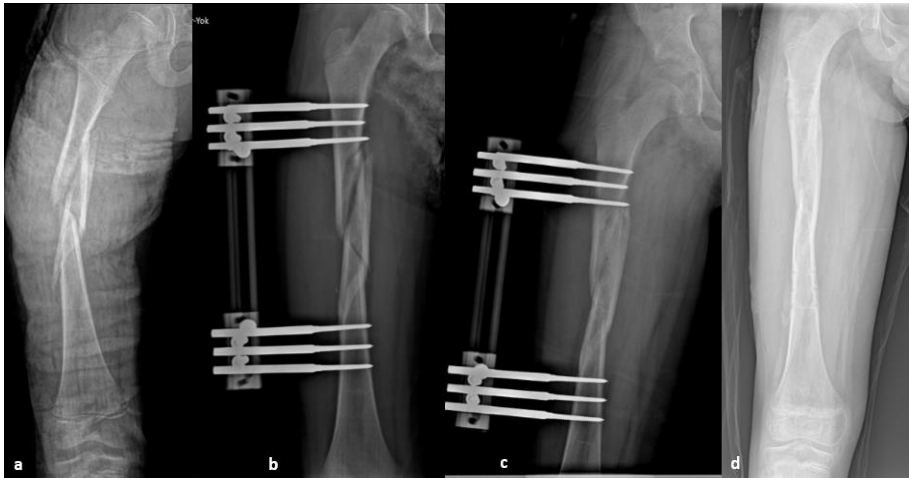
a-Radiography with a diagnosis of Class 4 pediatric left femur fracture.
